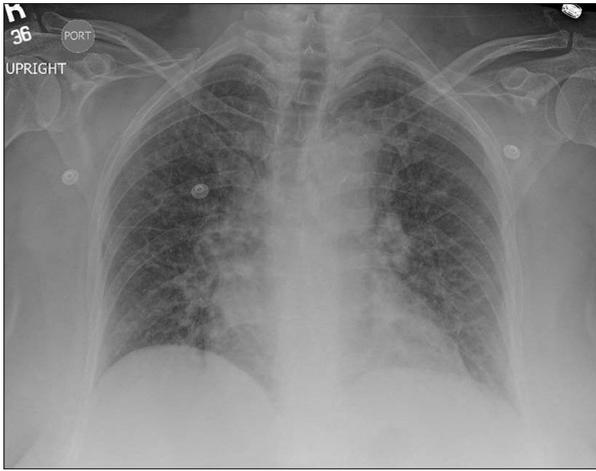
Portable chest X-ray with no focal abnormalities.
